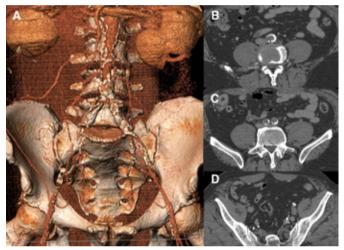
Post-operative CTA of the 1st patient treated with the CERAB technique; Panel A, 3D reconstruction and B-D, axial views.
